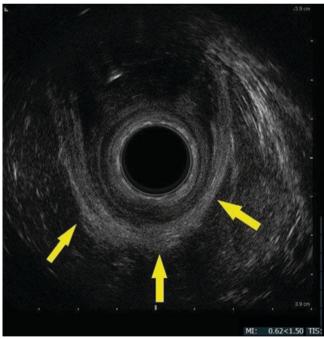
Two-dimensional endoanal ultrasonographic appearance of the upper anal canal, highlighting the U-shaped puborectalis (arrows)
